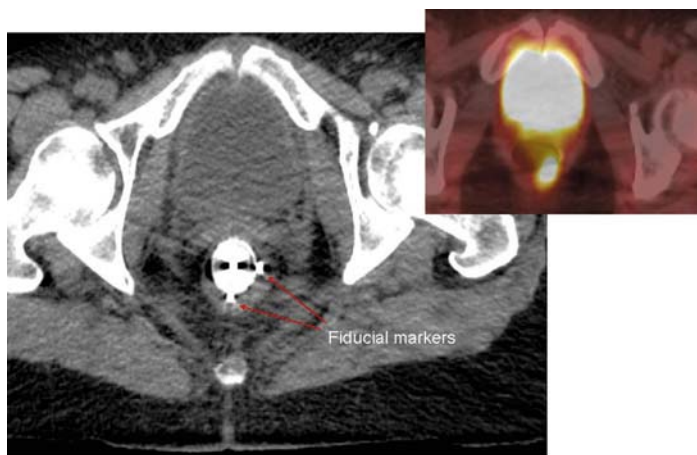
Rectal applicator in place for administering brachytherapy radiation. Note fiducial markers are placed on either side of the tumor demonstrated with PET/CT imaging
